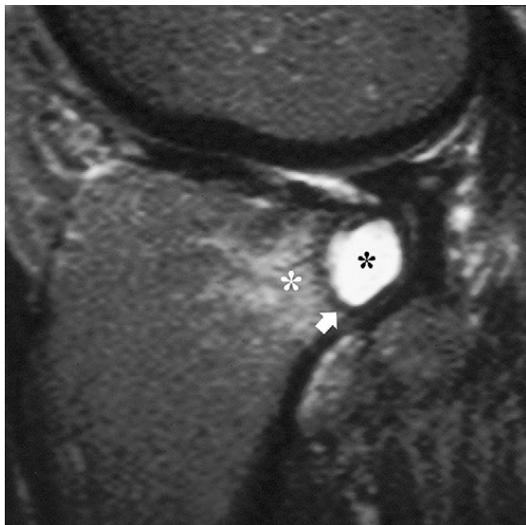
Subchondral cyst in the proximal tibia. Sagittal T2-weighted spin-echo MR image of the proximal tibia shows a small, well-defined, fluid-like mass, adjacent to the articular surface (*black asterisk*). Note subtle adjacent edema-like signal (*white asterisk*) and marginal sclerosis (*arrow*).
